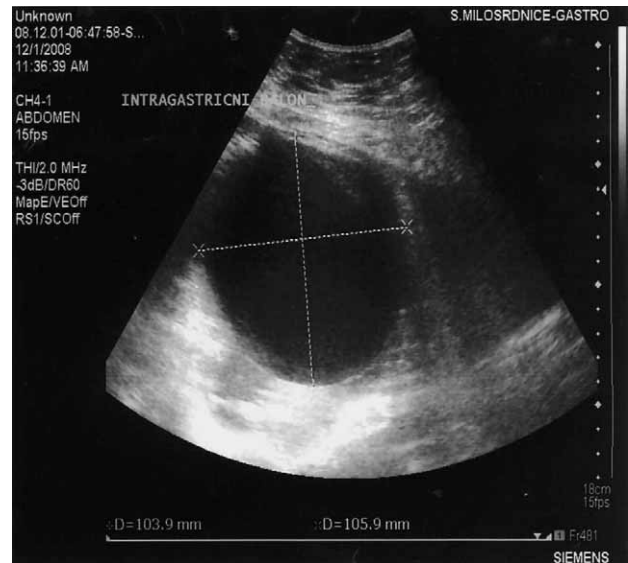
Transabdominal ultrasound (t-USD) control of balloon's position and morphology i.e. fuction.
